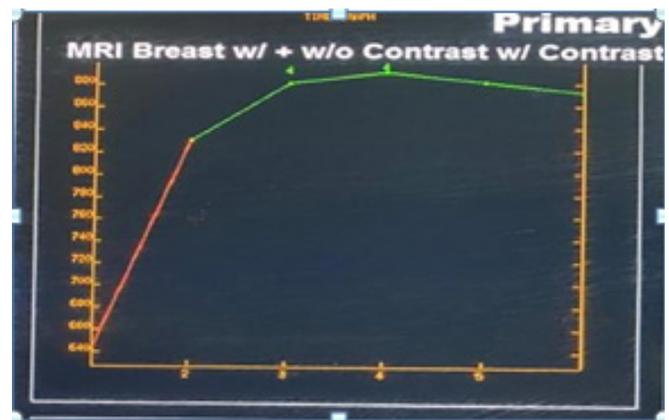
MRI time-intensity kinetic enhancement curve shows wash out - type III curve. Biopsy results were consistent with fat necrosis
